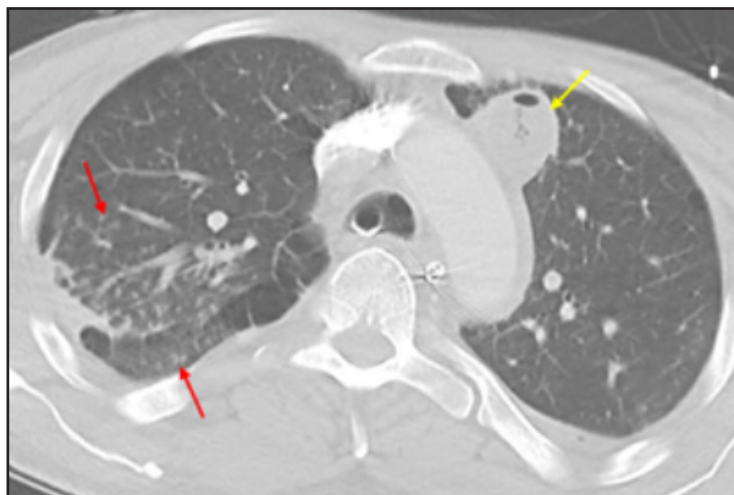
Aspergillosis. Axial contrast-enhanced CT image of an immunocompromised patient with disseminated aspergillosis demonstrating a left upper lobe cavitary lesion (yellow arrow) and right upper lobe tree-in-bud opacities (red arrows).
